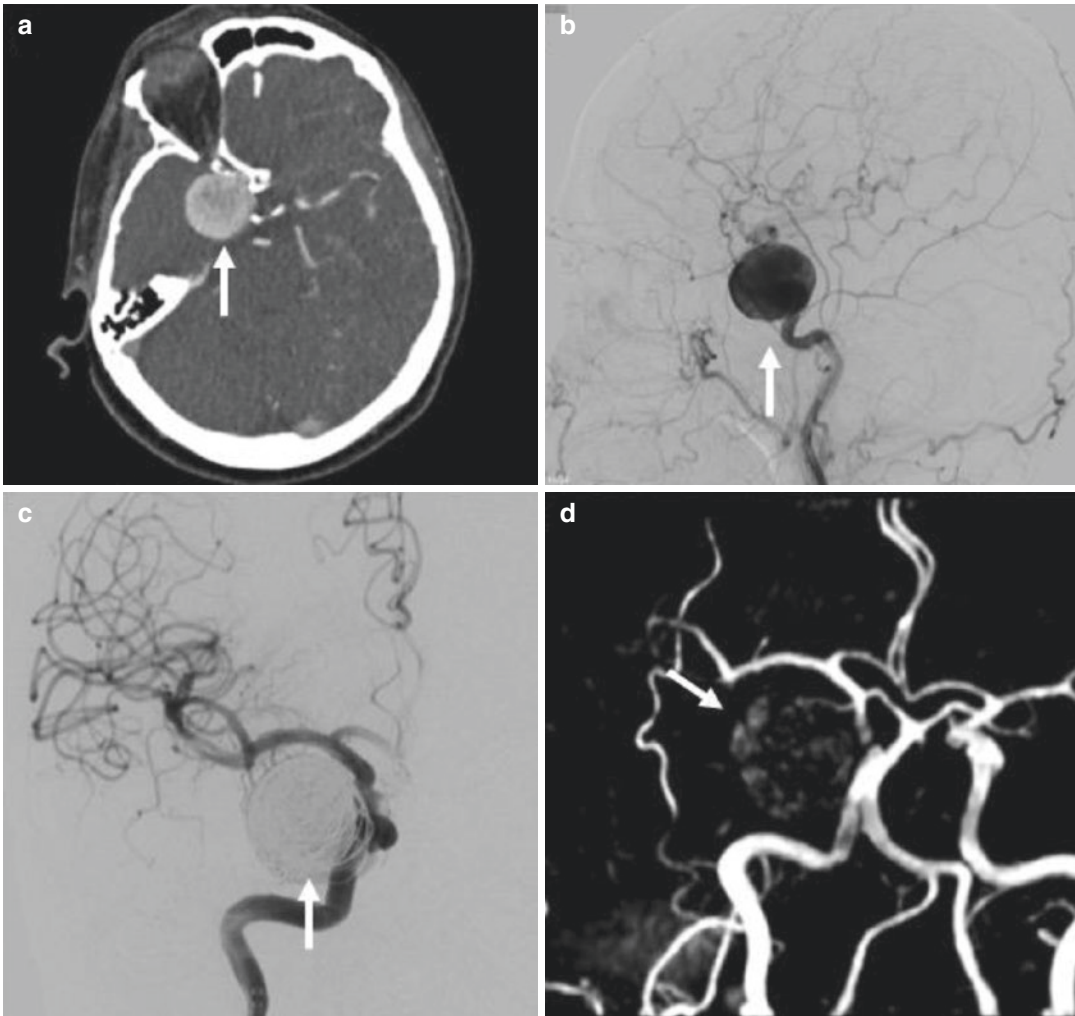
CTA (a) and selective DSA of the right internal carotid artery (b) before treatment reveals a giant carotid ophthalmic aneurysm. DSA (c) and 2D TOF MRA (d) of the same aneurysm after coil embolization
